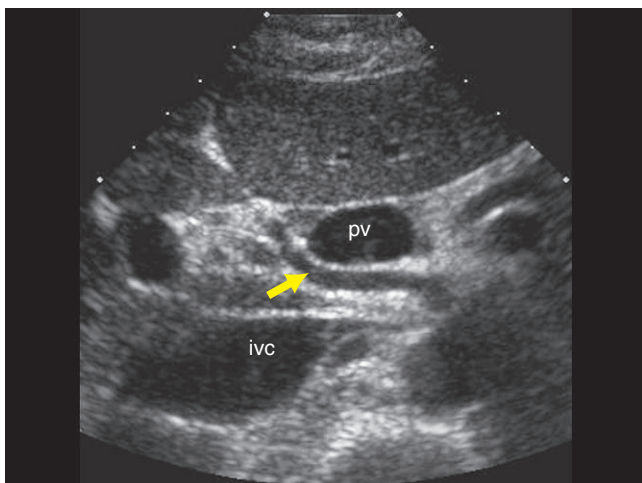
Transverse ultrasound of upper abdomen showing a tubular structure (arrow) posterior to portal vein (pv) that corresponds to replaced right hepatic artery. (Inferior vena cava = ivc).
